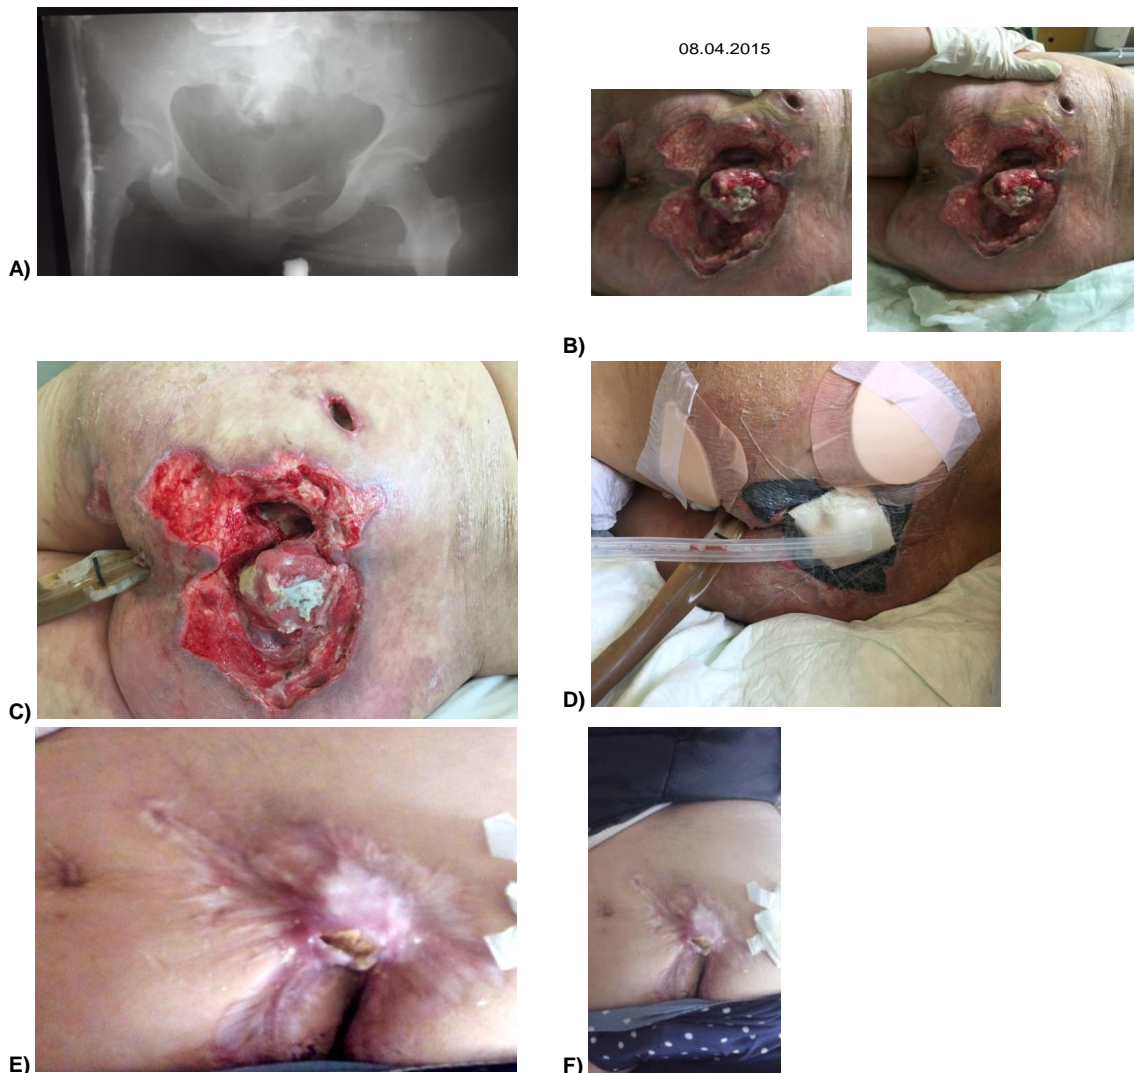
A) X-ray of pelvic vertical share fracture; B) situation before starting with treatment; C) Application of FMS; D) Application of VAK system; E, F) situation after the treatment
